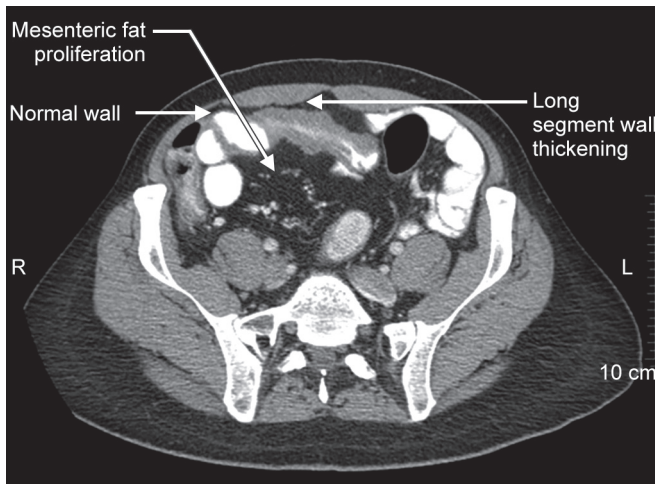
Computed tomography showing mesenteric fat proliferation and long-segment wall thickening
